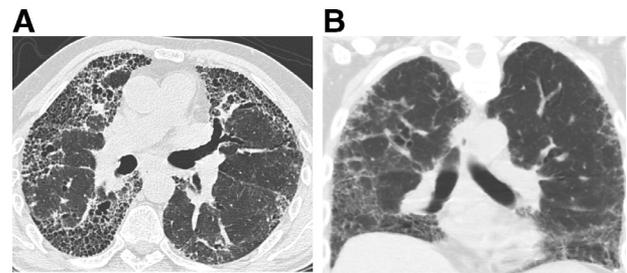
Axial (A) and coronal (B) images from HRCT demonstrate peripheral and basilar predominant reticulation, traction bronchiectasis, and subpleural honeycombing consistent with UIP, obviating open lung biopsy given this CT pattern's high positive predictive value for UIP on pathology.
